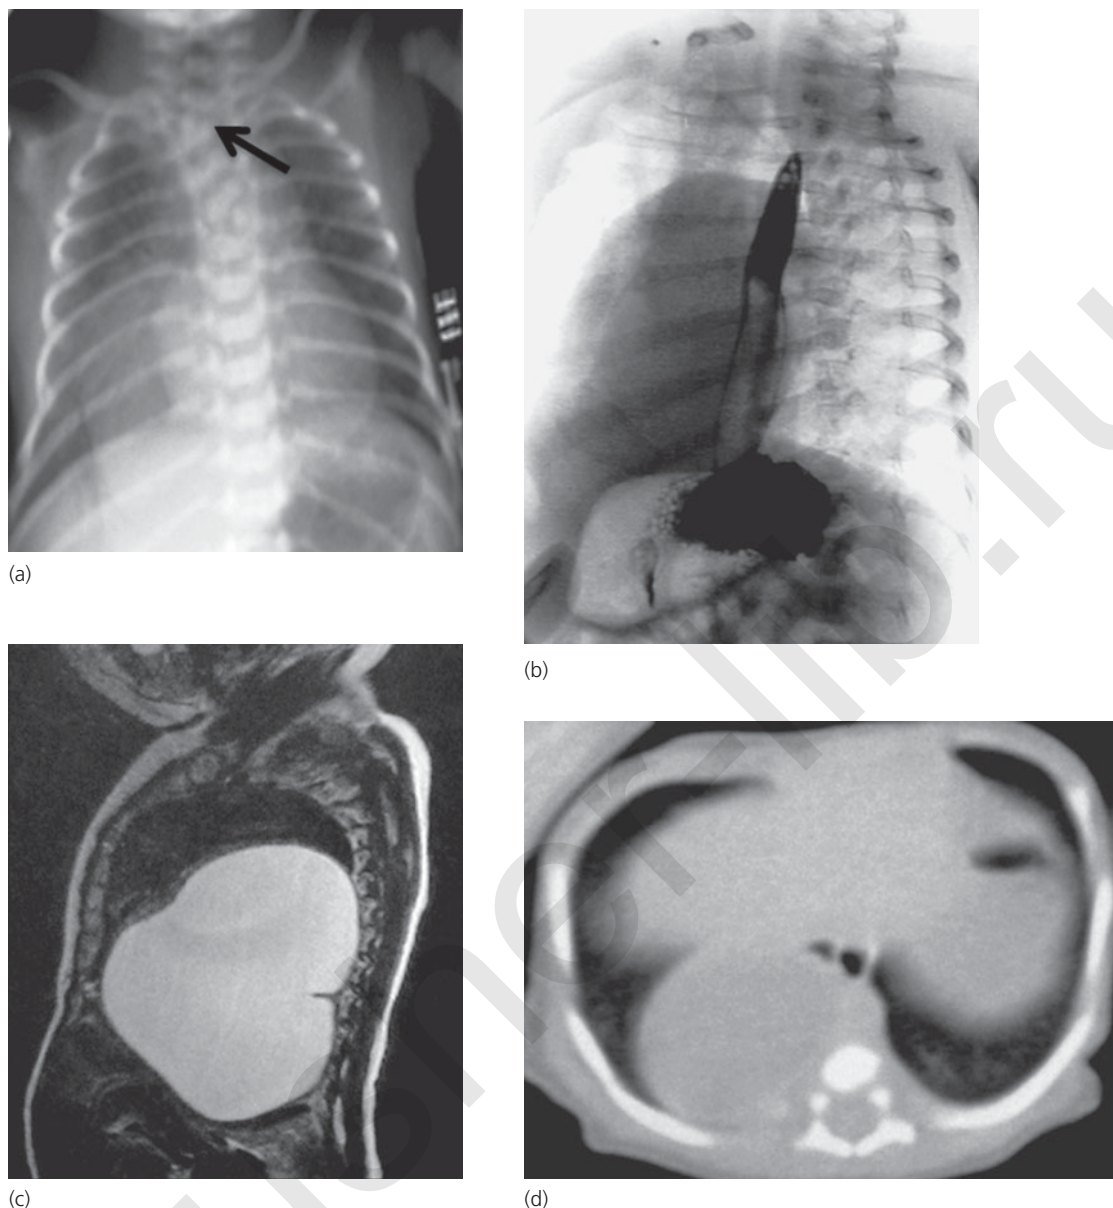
(a) Chest x-ray showing vertebral anomalies in an antenatally detected foregut duplication cyst. (b) Contrast study demonstrating a large posterior mediastinal duplication cyst. (c) Magnetic resonance imaging was done to rule out neuroenteric component in the presence of vertebral anomalies. (d) Computed tomography confirmed a smooth low attenuation posterior mediastinal duplication cyst.
